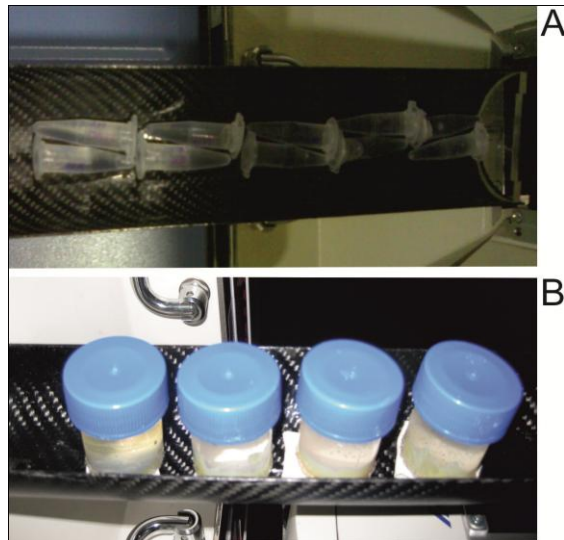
Eppendorf tubes (A) and Falcon tubes (B) with different solutions of Me₂SO placed into the CT bed ready to be imaged
